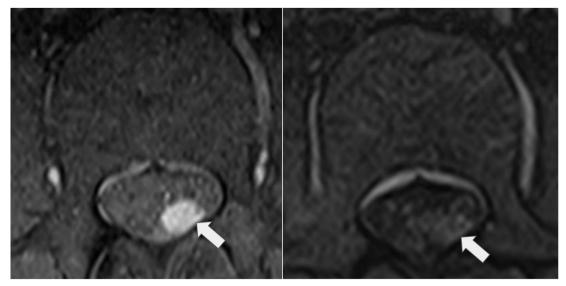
From left. T1-weighted MRI image of L2 intradural lesion post-gadolinium, prior initiation of ATT (arrow); corresponding MRI image after 2 weeks of ATT, showing reduction in enhancement of the L2 intradural lesion. (arrow)
